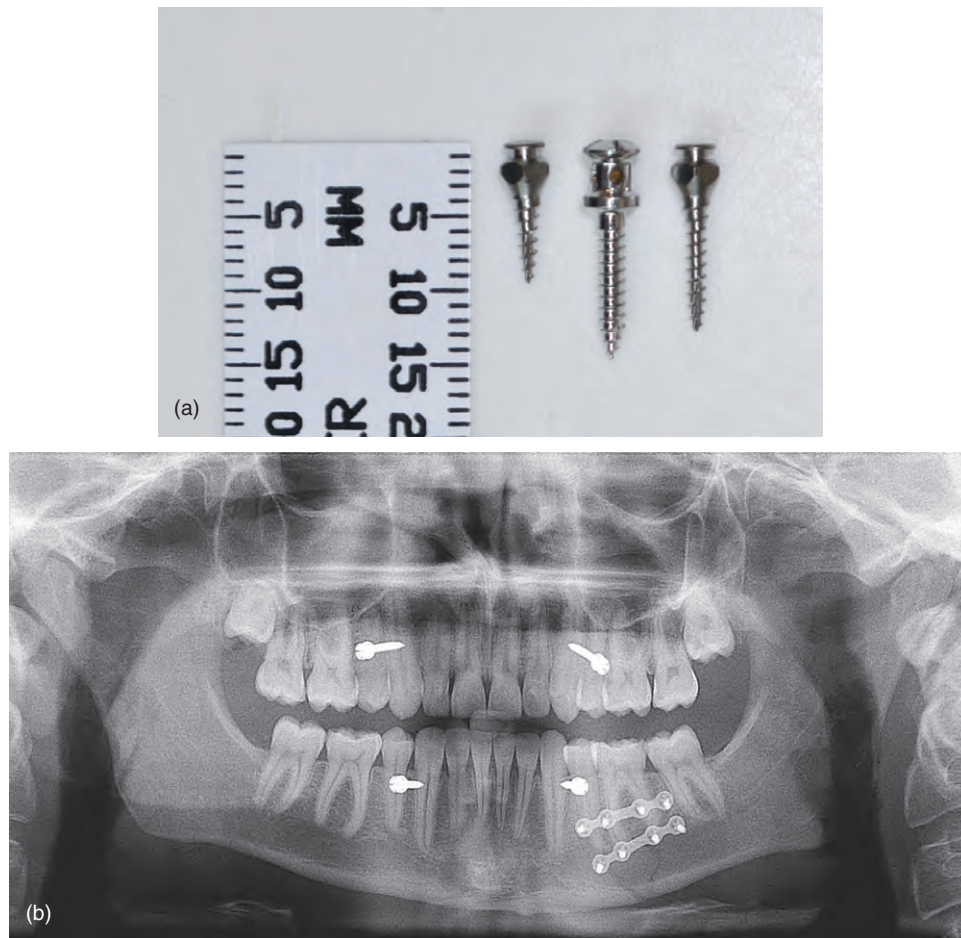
(a) Photograph of 6 (left) and 9 (right) mm length IMT mini-implant versions with an IMF screw in the centre. (b) Panoramic radiograph showing close root proximity and poor mesio-distal orientation of IMF screws in a trauma case.
